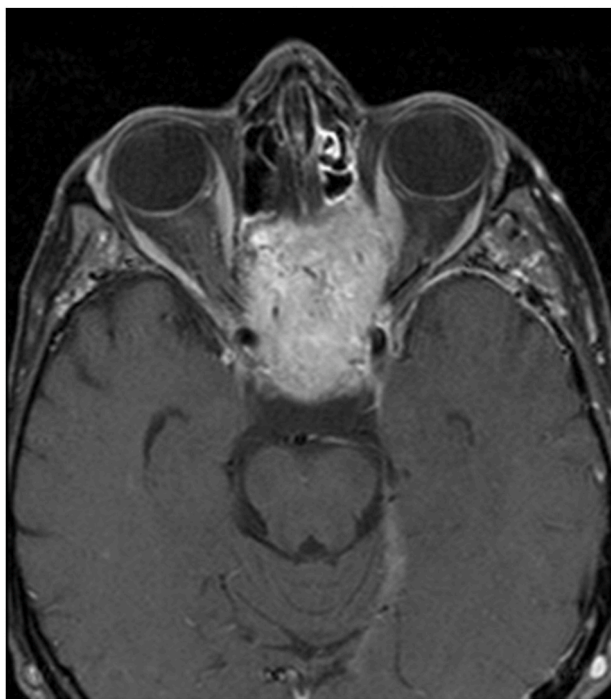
Axial post contrast T1-weighted MRI revealing a large mass within the ethmoids and skull base with displacement of the left medial orbital wall and obliteration of both optic canals.
